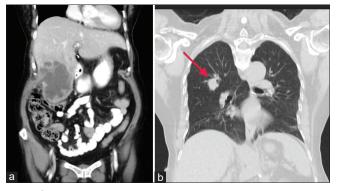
(a) A computed tomography scan of the chest and abdomen performed 4 months after surgery revealed a large hypo-enhancing hepatic mass in segment V. (b) An irregular 2-cm lung nodule was identified in the right upper lobe (arrow). Both findings were suggestive of recurrent tumors
